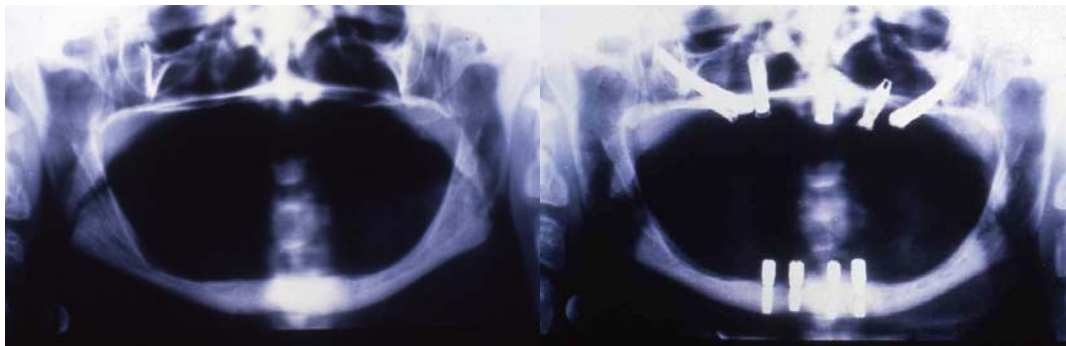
A) Preoperative panoramic X-ray view of a patient with maxillary atrophy. B) Postoperative panoramic X-ray view of rehabilitation with two zygomatic implants and three standard implants in the anterior zone of the upper maxilla.
